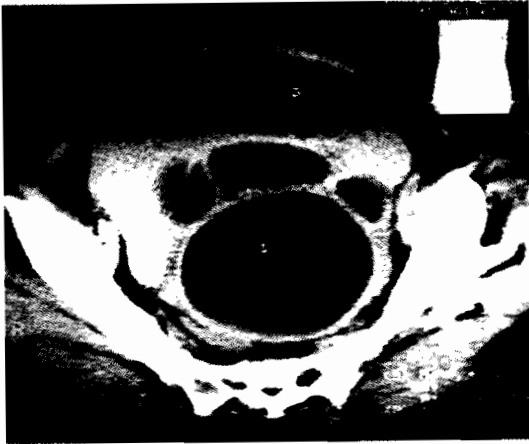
CT scan showing multiseptate retrovesical hydatid cyst compressing the urinary bladder anteriorly.
